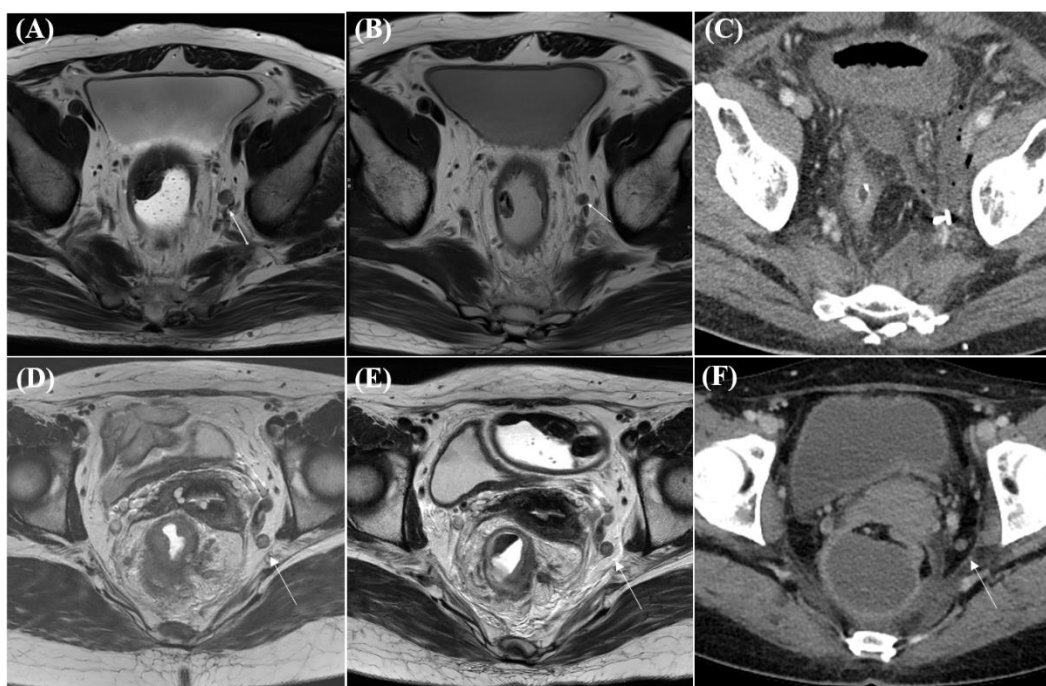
Assessment of residual LLNs after LLND. (A), (B), and (C) show case where LLNs were successfully removed through LLND, while (D), (E), and (F) display case where LLNs remained after the procedure. The left proximal internal iliac LN (arrows) in pretreatment MRI (A) and restaging MRI (B) was not visualized in the postoperative APCT (C), leaving postoperative change with fluid and air bubbles. This proximal internal iliac LN was dissected and the left LLN metastasis was reported in the pathologic report. Another case of left distal internal iliac LN (arrows) showed a remaining LLN in the postoperative APCT (F), compared with pretreatment MRI (D) and restaging MRI (E). The surgical record included the full extent of LLND, and pathology reported no LLN metastasis despite the residual distal internal iliac LN.
